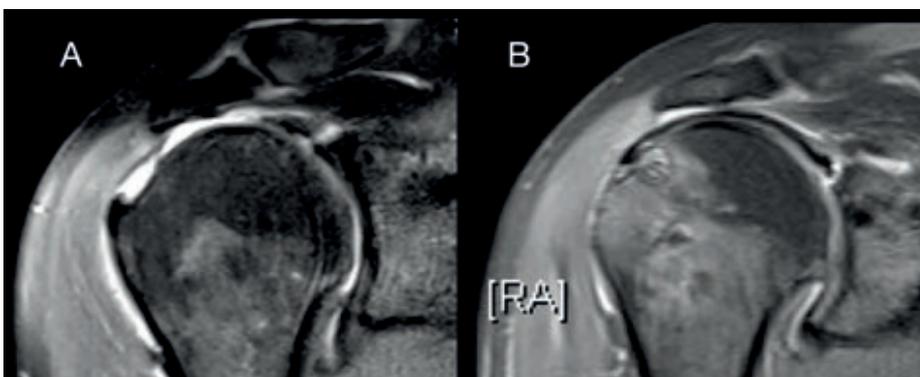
MRI scans of superior capsular reconstruction. A = before and B = one year post-operatively (images courtesy of Lennard Funk www.shoulderdoc.co.uk)
